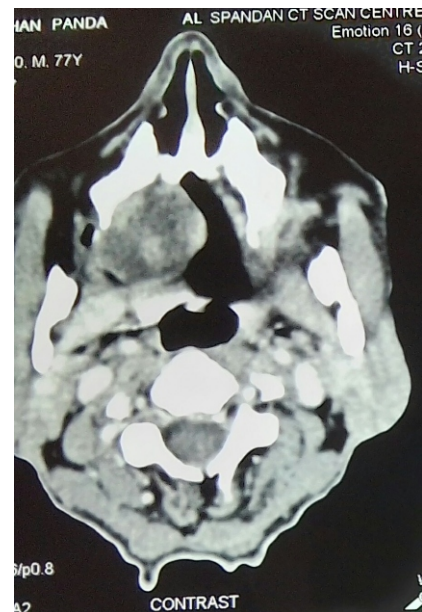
CT Scan showing the tumour
